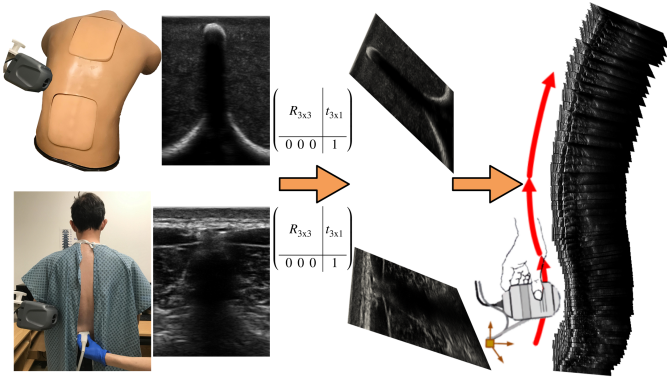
Freehand 3D ultrasound imaging of the spine
